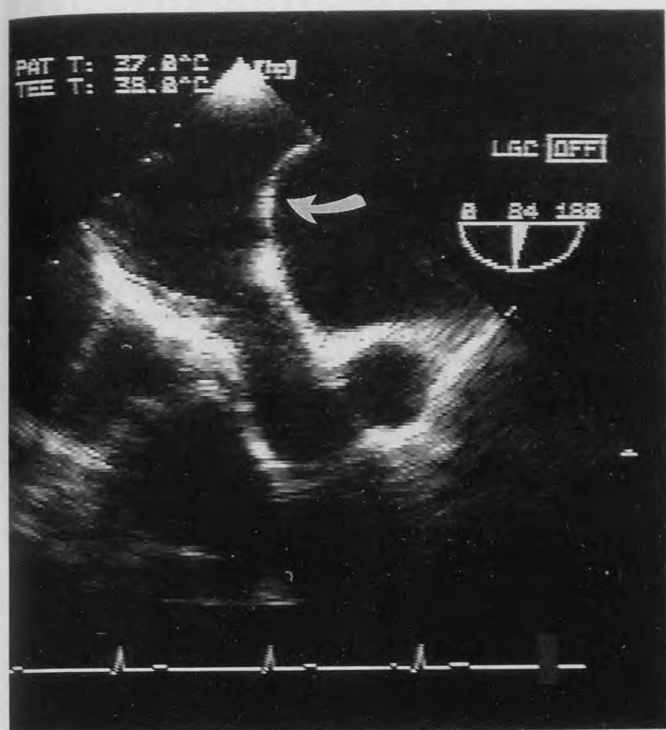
Transesophageal echocardiogram, showing the atrial septal aneurysm (arrows) bulging into the right atrium in diastole (*left*) and the left atrium in systole (*right*). The circular structure below the left atrium is the aorta.
